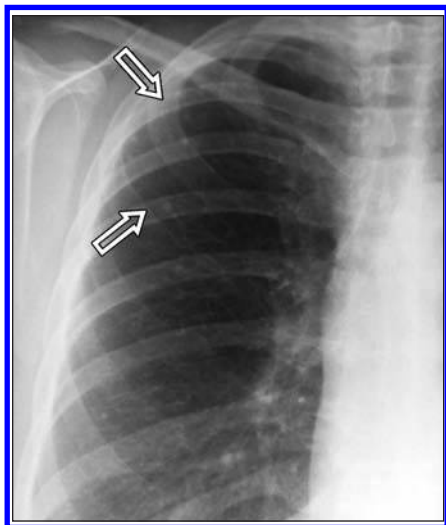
Metastatic pulmonary calcification. Posteroanterior chest radiograph shows multiple punctuate calcifications (arrows) in upper lung zones. Patient had no history of tuberculosis or varicella pneumonia.
